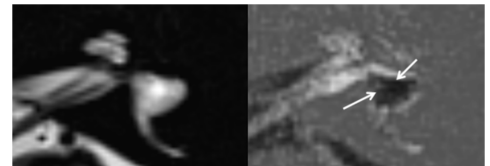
A 65-year-old man with an aplastic left lateral semicircular canal (LSCC). In this patient, the area of the central bony island (CBI) of the left LSCC is 0.0 mm². MR images were obtained 4 hours after intravenous administration of a single dose of gadolinium-based contrast material. MR cisternography (left image) shows the total lymph fluid space as a bright signal. The HYDROPS2 image shows the extremely dilated vestibular endolymph area as a black space (arrows, right image).
